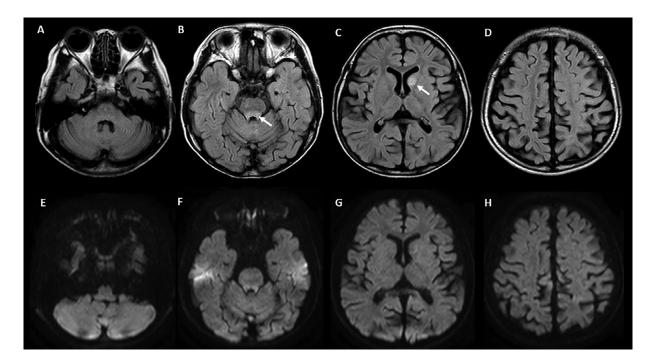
MRI at age 10 years shows mild cerebral atrophy. FLAIR (TR/TE/TI, 8000/140/2400 msec, slice thickness/gap, 5/1 mm) images (A-D) show high signals in dorsal midbrain (B: arrow) and left caudate nucleus (C: arrow). DWI ($b = 1000 \text{ s/mm}^2$, TR/TE, 2365/60 msec, slice thickness/gap, 5/1 mm) demonstrates no restricted diffusion (E-H).
